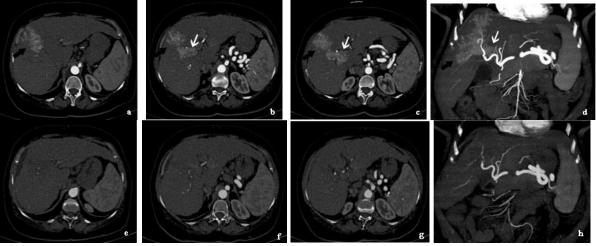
Baseline diagnostic CT scan in axial (a,b,c) and coronal reconstruction (d) views showed infiltrative hypervascular tumor in the right hepatic lobe mainly in segment VIII (black arrows) invading the right and main portal vein (white arrows).
